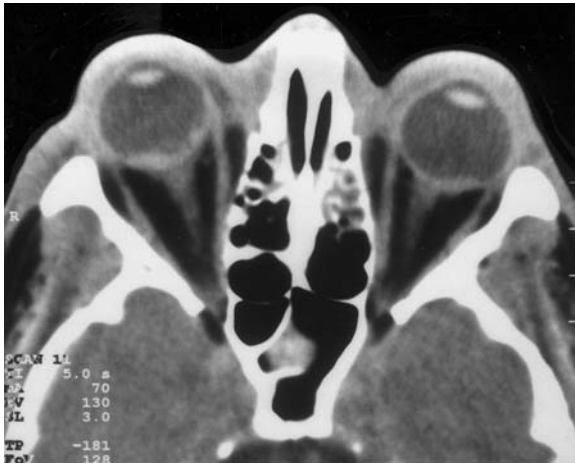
A 19-year-old man with vision loss after a black-powder explosion. Diagnosis: bilateral intravitreal hematoma, with detachment. Axial CT with small, bilateral, hyperdense fluid levels at the posterior circumference of both globes
